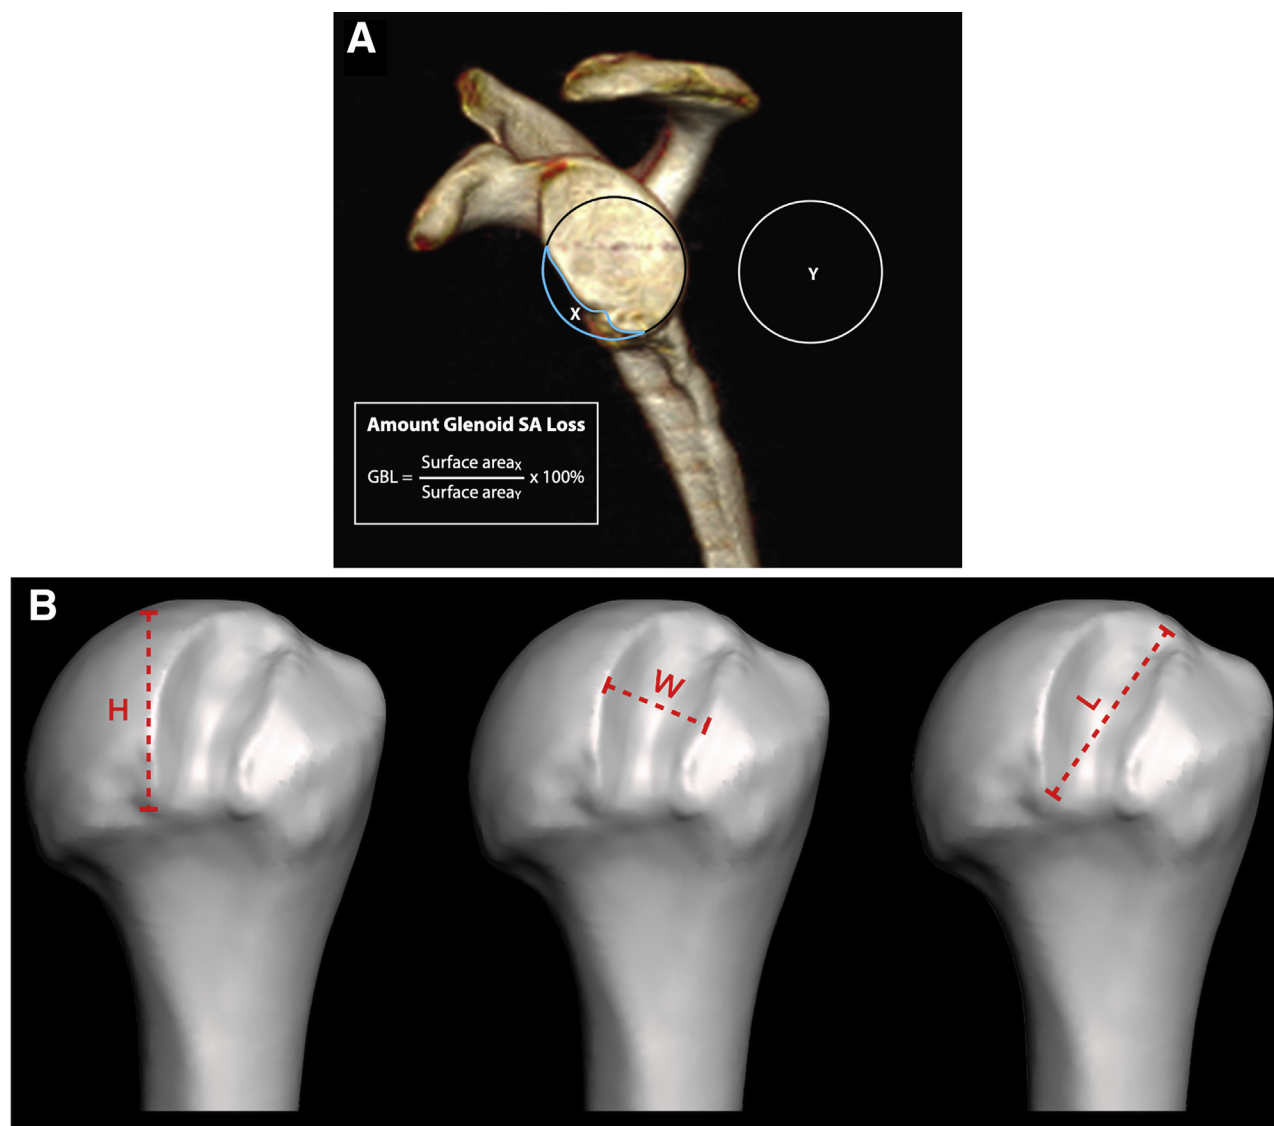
(A) Preoperative 3-dimensional (3D) computed tomography (CT) scan of glenoid with the humeral head subtracted to measure the amount of glenoid bone loss (GBL) present prior to arthroscopic Bankart repair. (B) 3D rendering of a preoperative right shoulder CT scan with the scapula removed, leaving only the humeral head for assessment. Preoperative CT scans with 3D renderings were performed for all patients enrolled and were used to measure the height (H), length (L), and width (W) of Hill-Sachs lesions, with these measurements being used to calculate the total volume of humeral head bone loss. SA, surface area.
